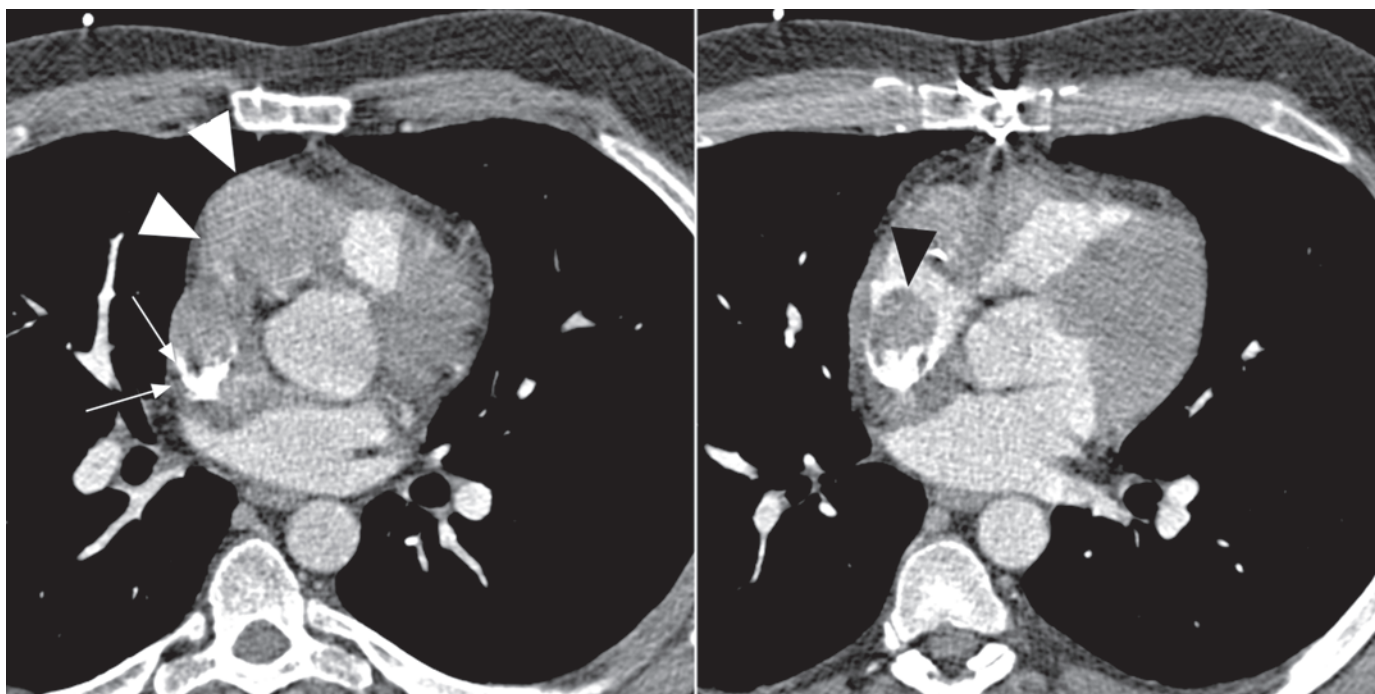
Multidetector-row CT images of a patient with recurrent angiosarcoma involving the right atrium and parts of the right ventricle (arrow heads). The mass almost occludes the superior vena cava (arrows).
